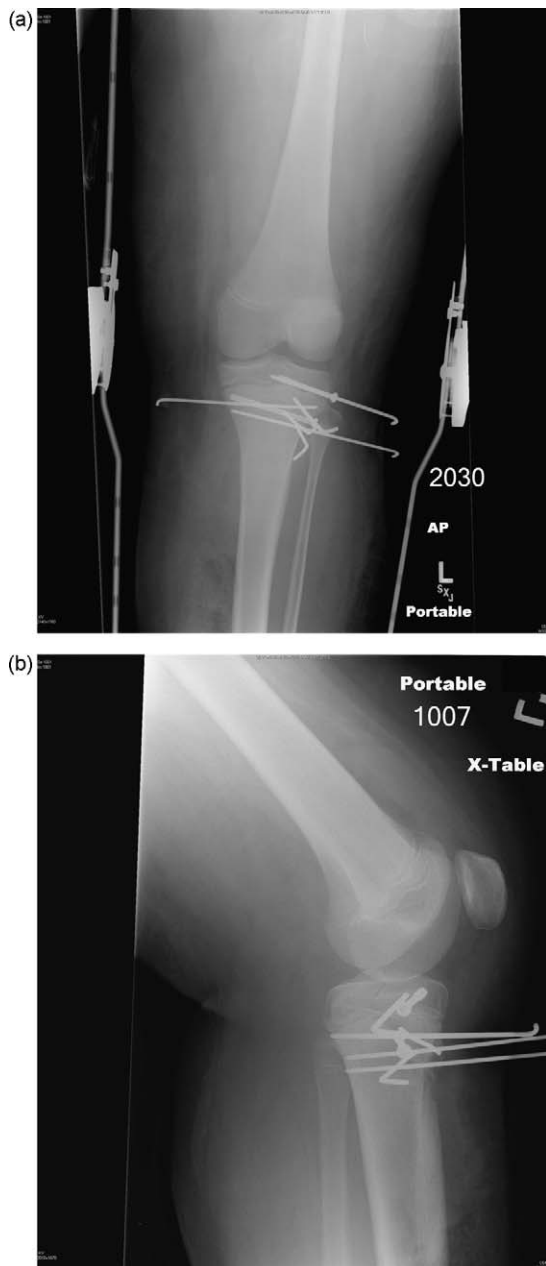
(a) Post-operative anteroposterior radiograph of left knee. (b) Post-operative lateral radiograph of left knee.
